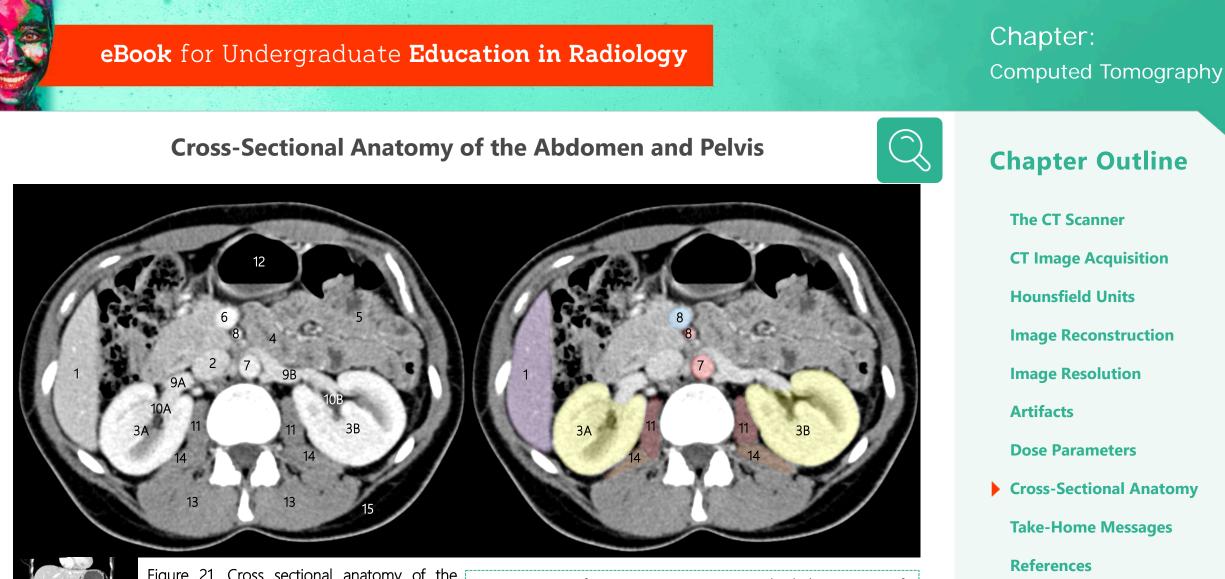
Cross sectional anatomy of the abdomen. Annotations of the greater blood vessels (A) and abdominal organs (B) in an axial reformatted CT image of the upper abdomen, acquired in the portal-venous phase.
